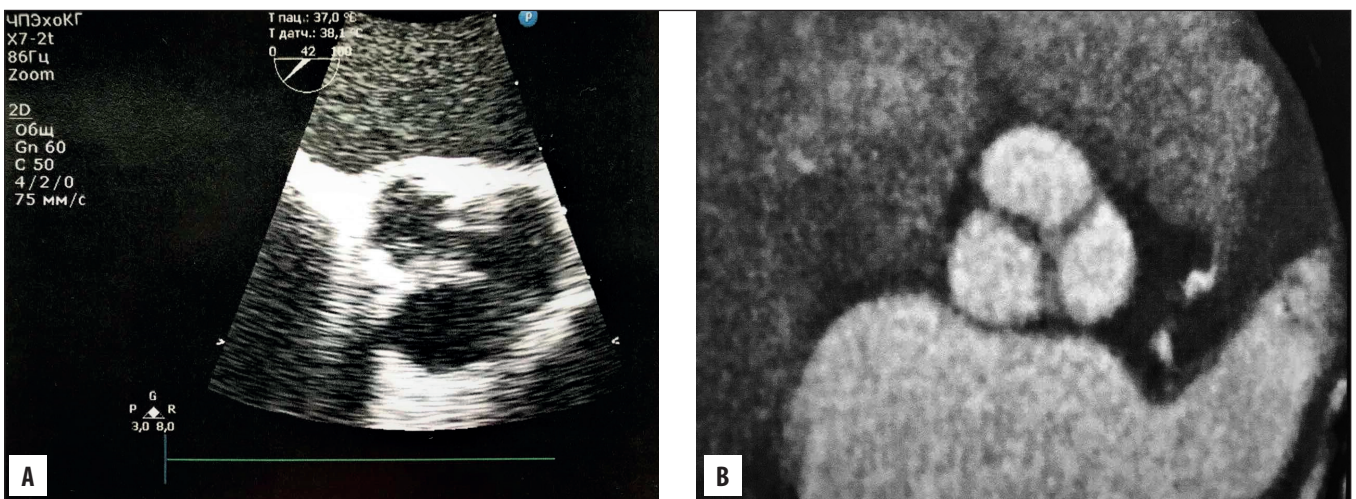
A). 2D transthoracic echocardiography, shot axis view shows severe calcified aortic valve B). CT scan demonstrates severe calcinosis in aortic valve cusps
